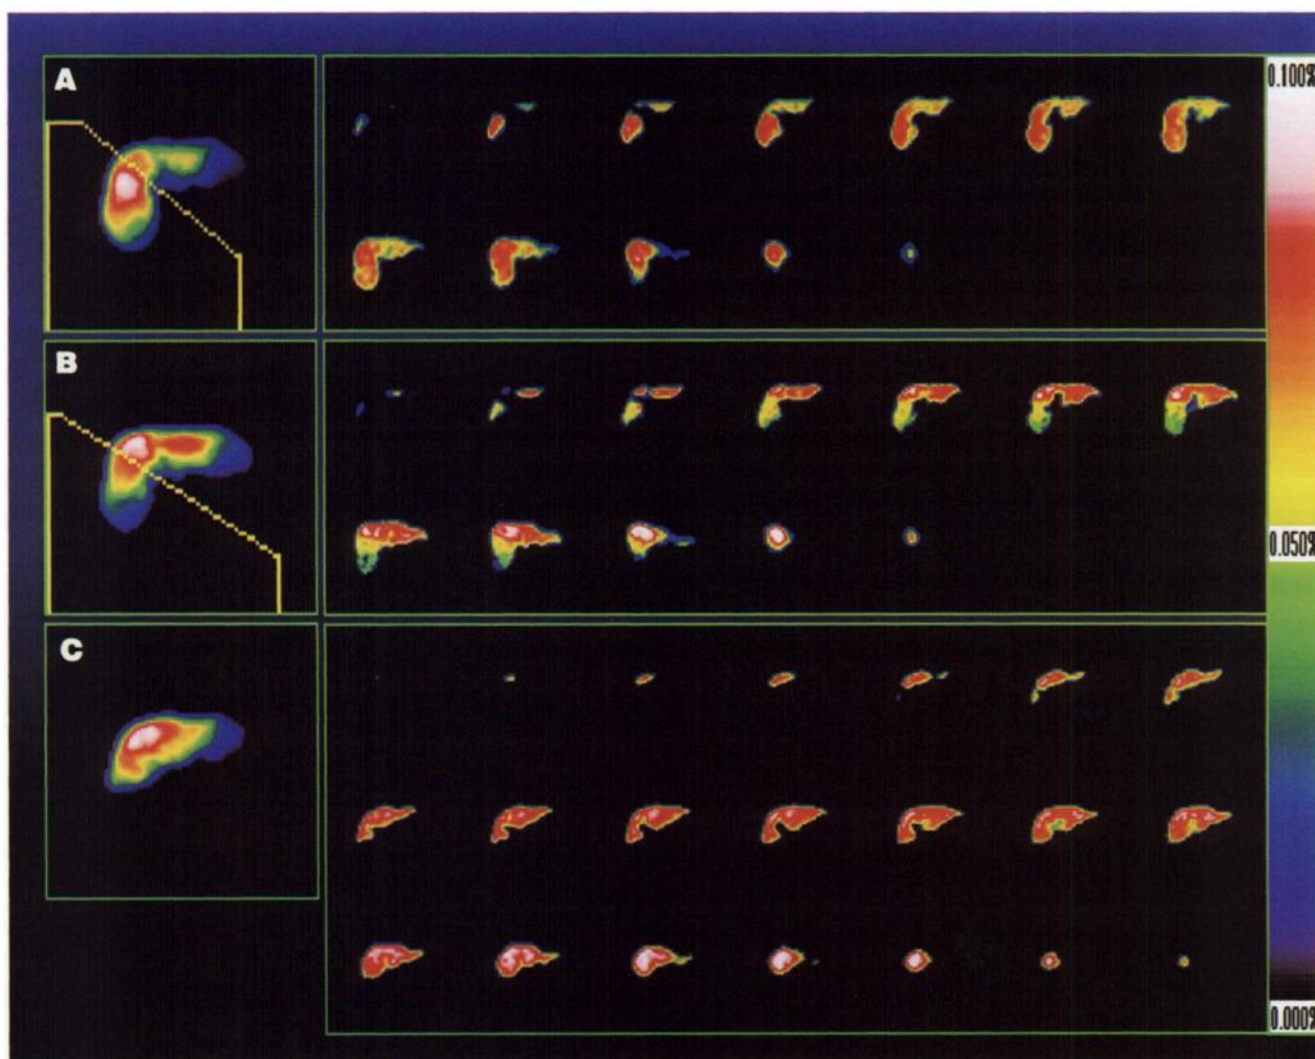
A 52-y-old man with cholangiocarcinoma in porta hepatis. SPECT images of ^{99m}Tc -GSA before (A) and after (B) PTPE and after hepatic resection (C) are shown. Left lobe showed hypertrophy after PTPE, and its radioisotope uptake was increased, although uptake of right lobe was decreased unevenly. After right lobectomy, remnant liver showed remarkable hypertrophy.
